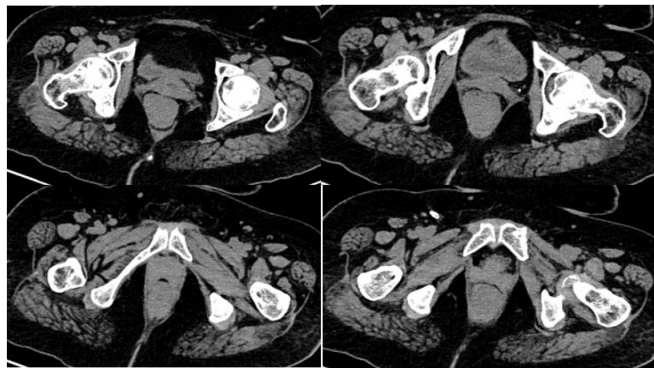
(A-D) Noncontrast CT Axial images reveal an irregular isodense mass in the anorectum partially occluding the lumen.
